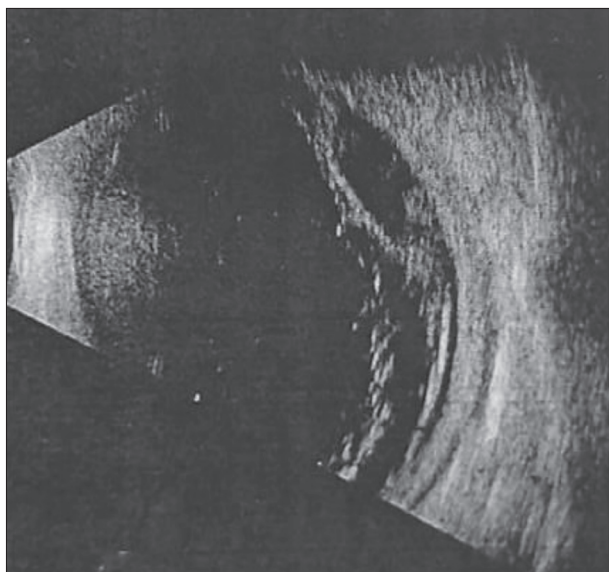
Ultrasound of the left eye shows the presence of mobile vitreous opacities of low to medium reflection (hemophthalmos), no echo signs of an intraocular foreign body, and the zone of high reflection of the detached retina
